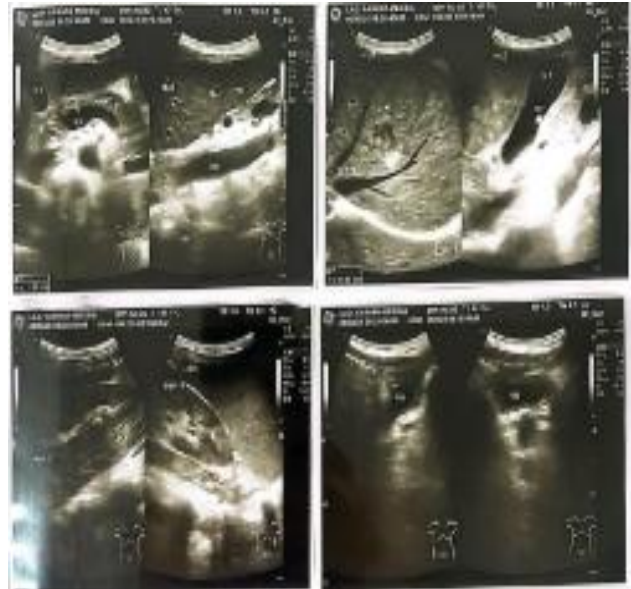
Abdominal ultrasonography demonstrated hepatomegaly and a 0.5 cm gallstone.
